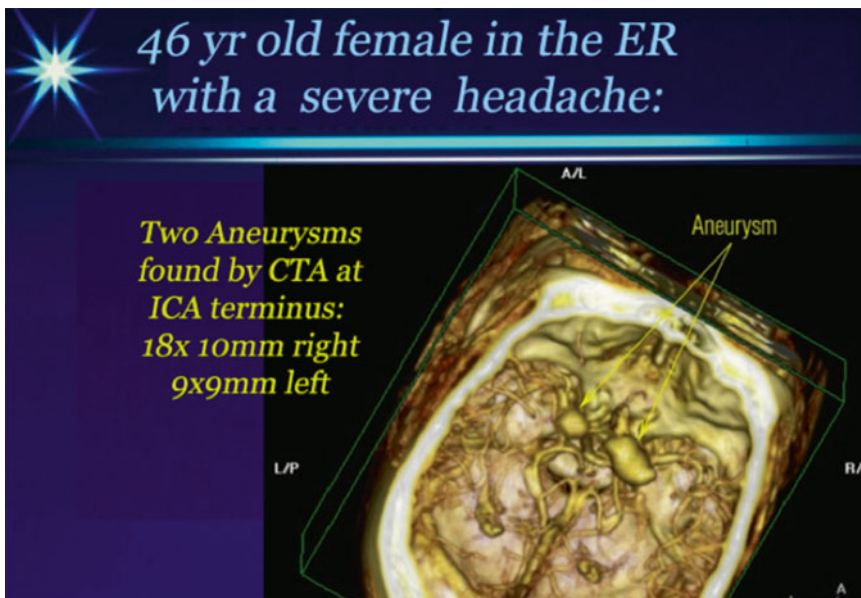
CT angiography aids in ER evaluations in revealing cerebral aneurysms
